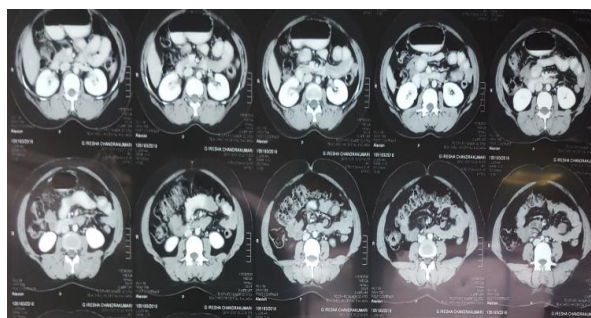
CT Abdomen showing pancreatic head neoplasm
